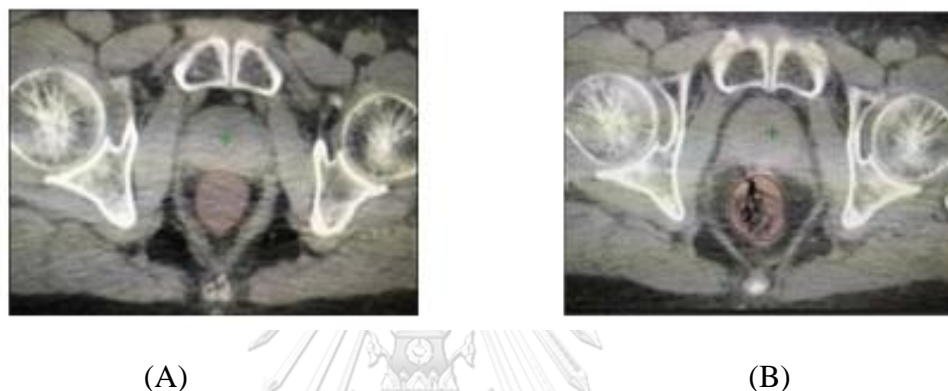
The changing of rectal volume during the radiotherapy course comparison between (A) planning CT and (B) CBCT before treatment
